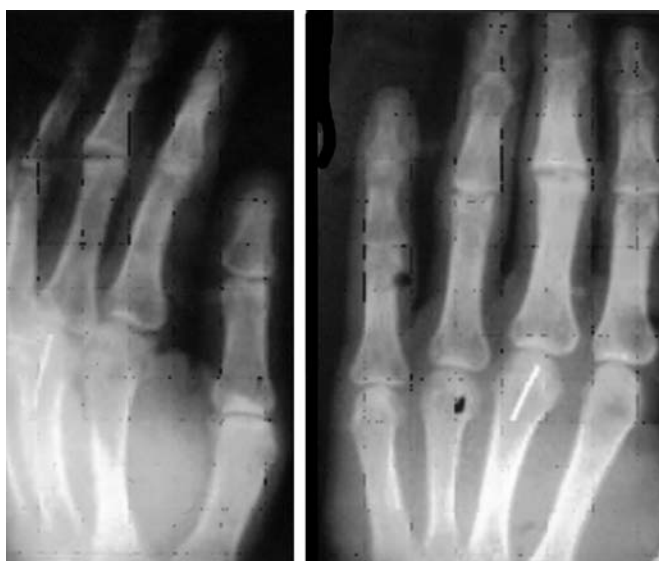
Postoperative X-ray for the same patient showing that the joint space has been reconstructed (3 months postoperative).
